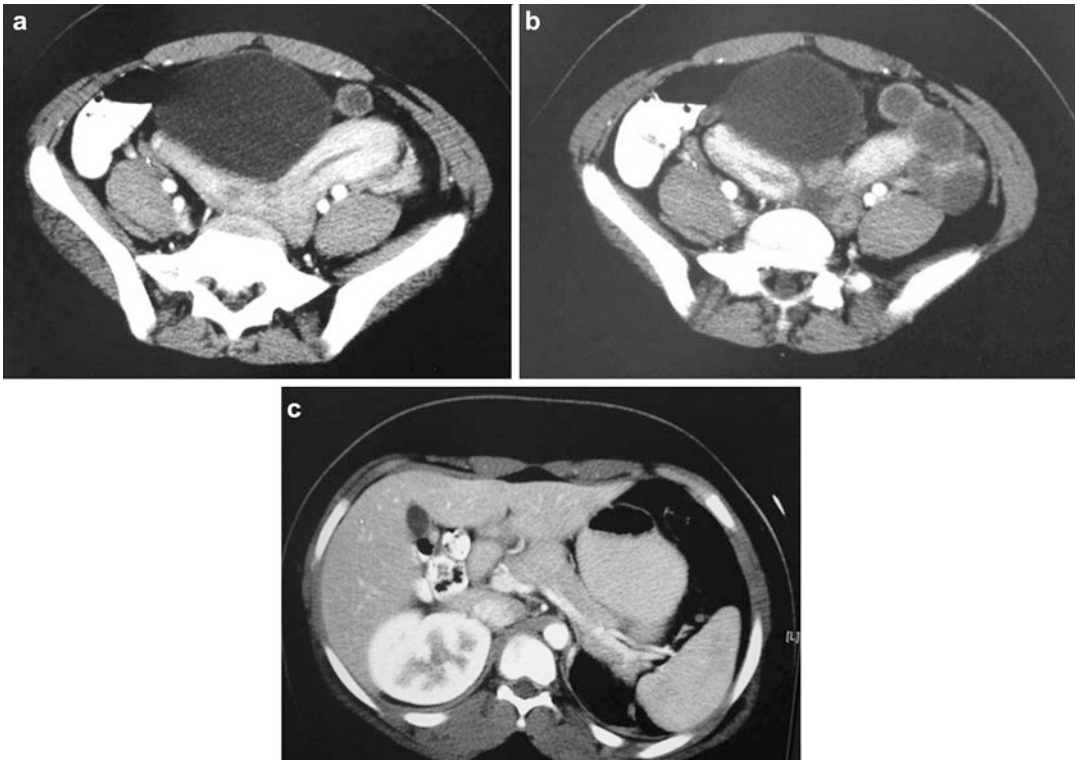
(a–c) CT scan of the abdomen and pelvis showed congenital uterine anomaly likely a didelphic uterus, the absence of left kidney, and the presence of hypertrophic right kidney
